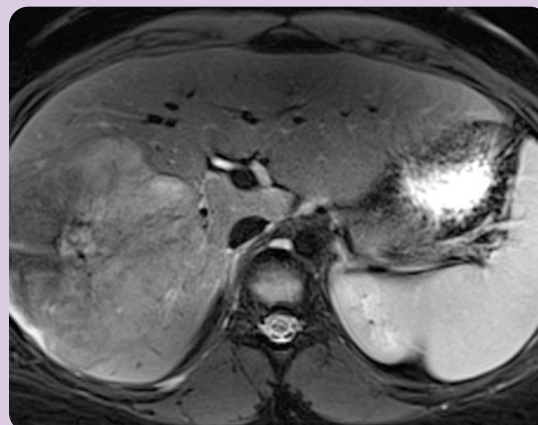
Axial T2-weighted FSE with fat saturation demonstrates a large fibro-lamellar carcinoma in the right liver lobe.
